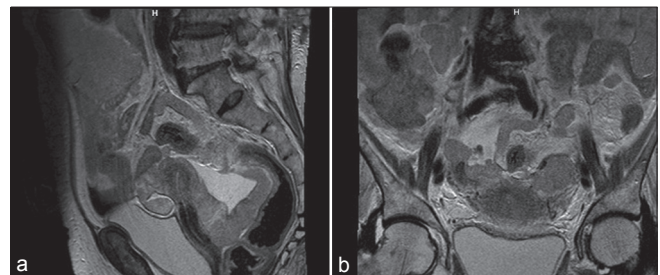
(a) T2 MRI shows uterus appear small and atrophic and thickened pelvic peritoneum. (b) T2 weighted MRI shows uterus and both adnexa appear unremarkable
